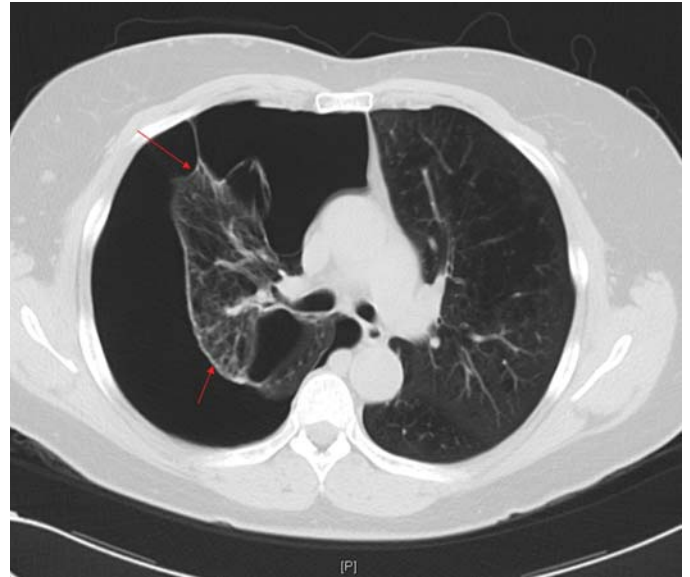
FIGURE e24-37 CT scan of large right-sided pneumothorax. Note significant collapse of right lung with adherence to anterior chest wall. Pleural reflection highlighted with red arrows. The patient has severe underlying emphysema.
